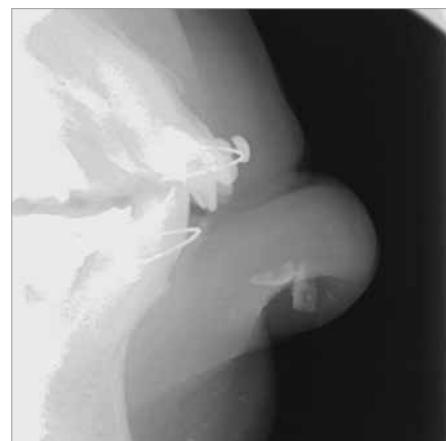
Soft tissue radiograph
